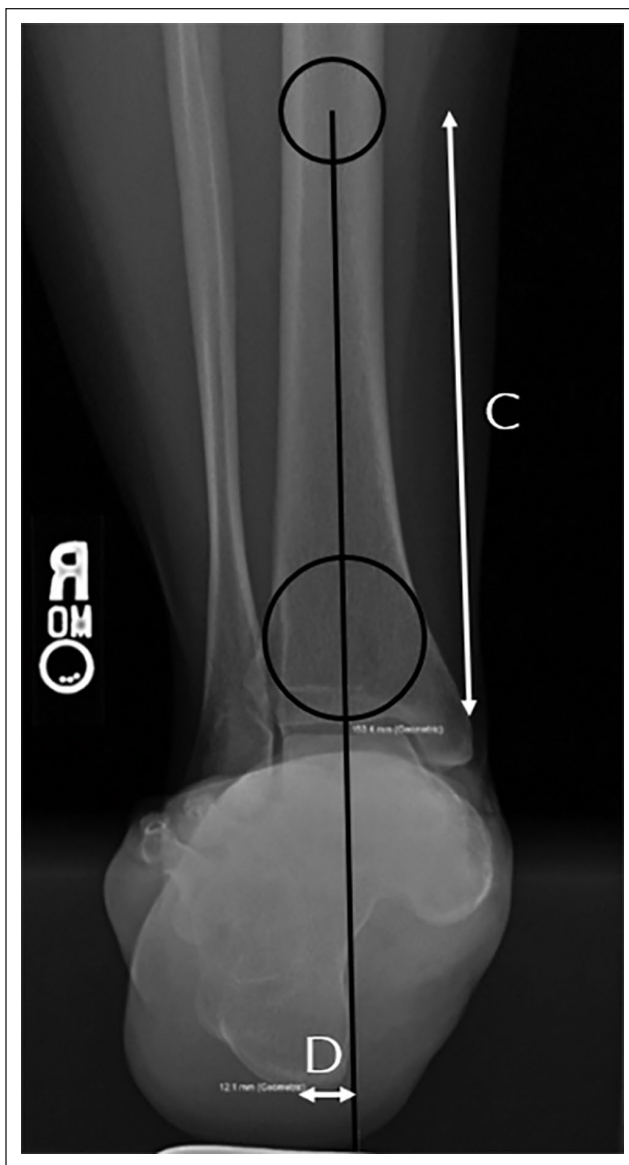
Method of determining hindfoot alignment utilizing hindfoot alignment view radiographs described by Saltzman and El-Khoury.⁴¹ Details of measurement and correction for magnification error are delineated in the corresponding section of the paper.
